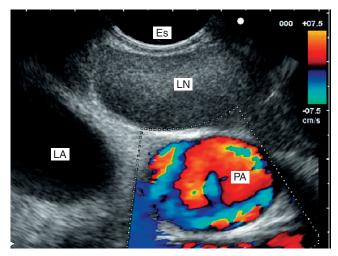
Subcarinal lymph node (LN) located between the esophagus (Es), pulmonary artery (PA), with color Doppler signal, and left atrium (LA).
